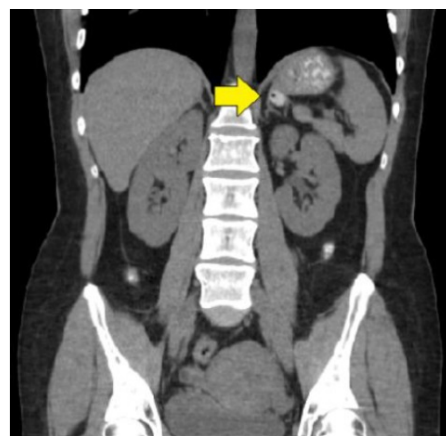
CT-scan-coronal section where saccular image is observed with contrast medium and air inside.
